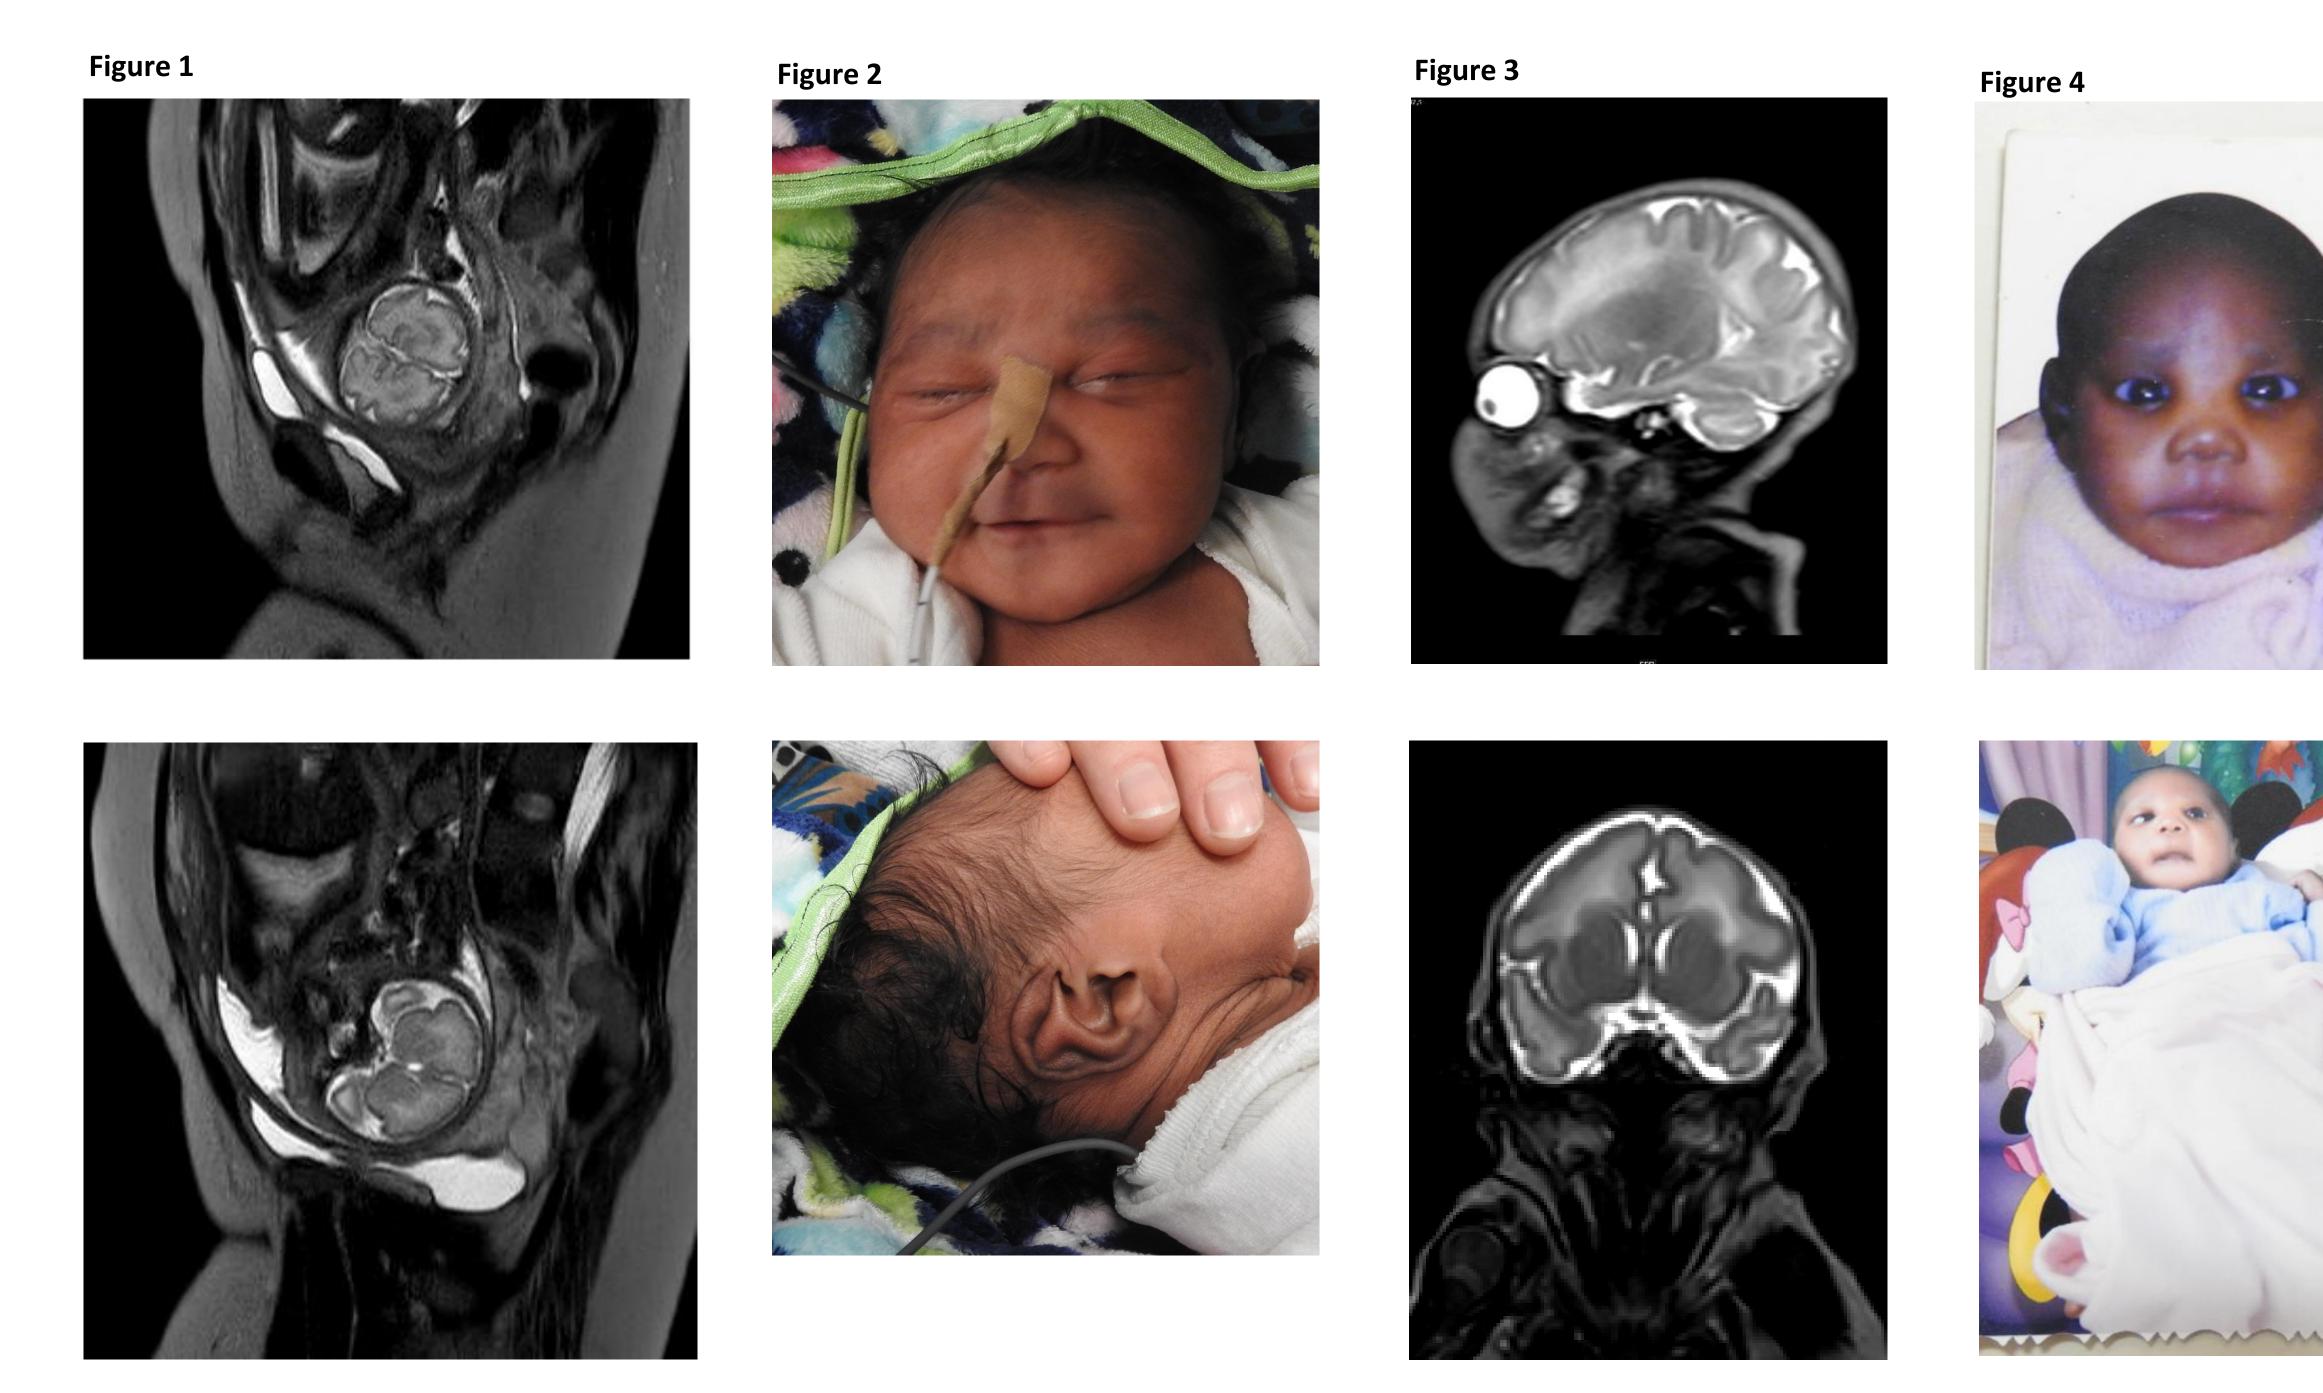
MRI during pregnancy showing bilateral frontal pachygyria Figure 2: clinical pictures of the index case Figure 3: postnatal MRI confirming the suspicion of bilateral pachygyria
